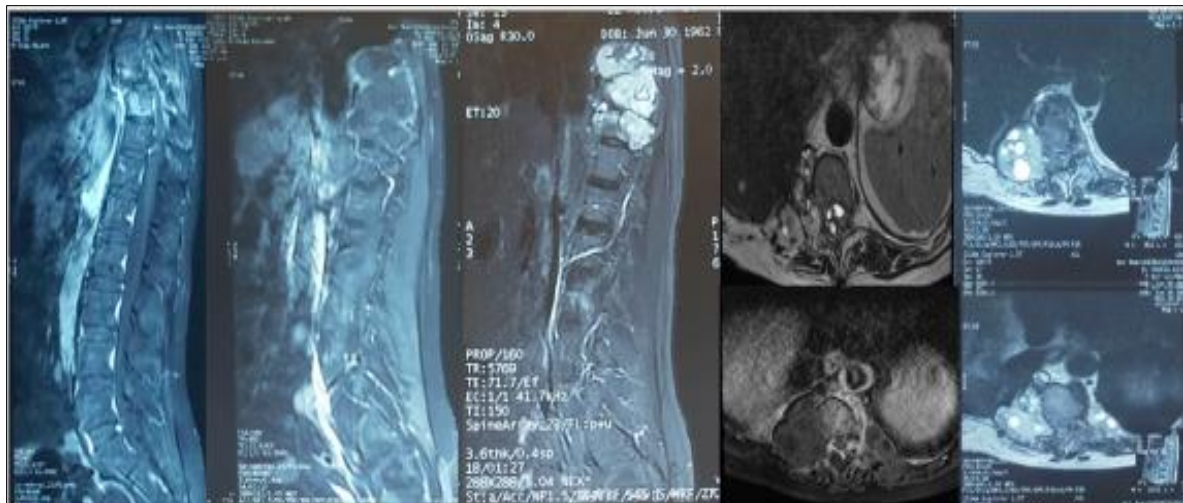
Axial and sagittal T2 and T1 weighted Magnetic resonance imaging (MRI) with contrast enhancement showing a right costo-vertebral process extended from T7 to T12, with polylobed tissue contours not enhanced after injection of gadolinium containing rounded cystic formations related to hydatid vesicles, extending to the medullary canal
